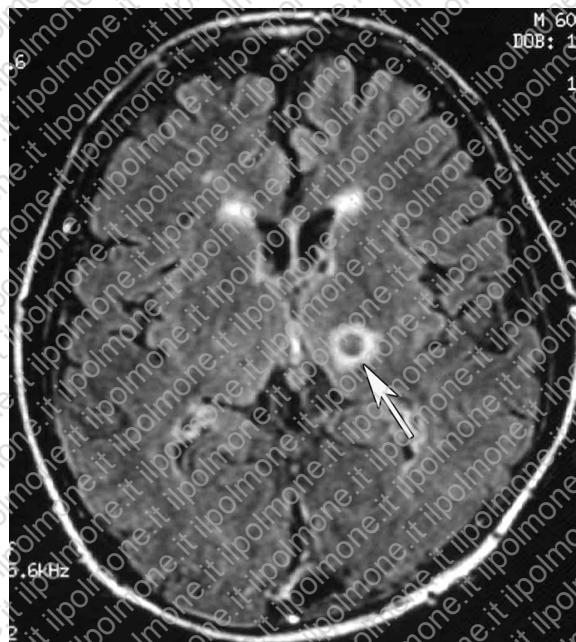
Neurosarcoidosis in a 60-year-old man who presented with decreased visual acuity and lower cranial nerve paresis. Axial fluid-attenuation inversion-recovery (FLAIR) MR image shows a left-sided thalamic mass with a ringlike appearance (arrow).
